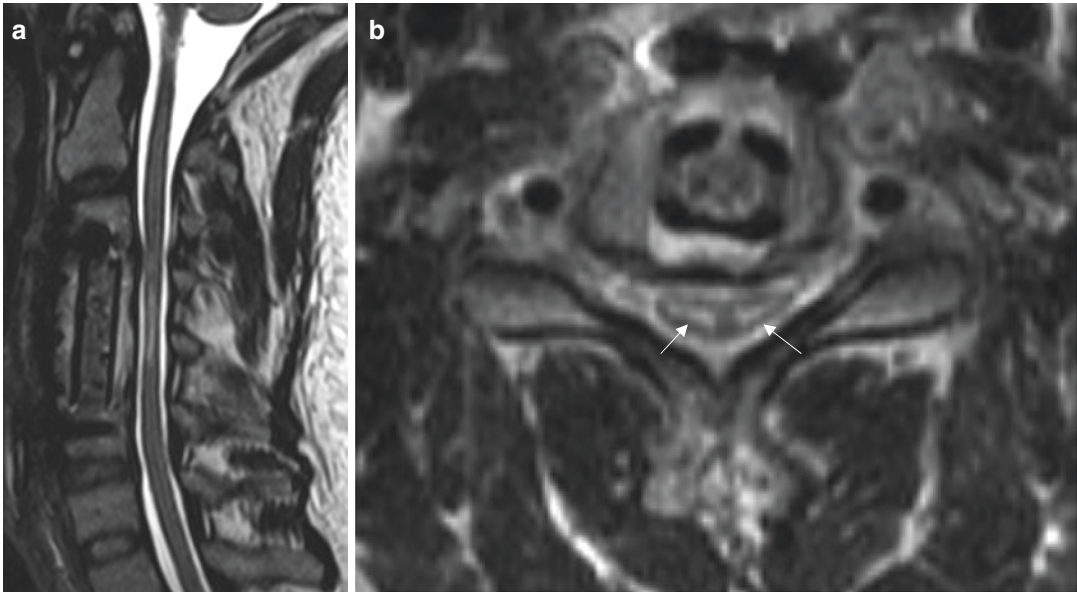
(a) Sagittal T2-weighted image in a postoperative patient demonstrates cord thinning and T2 hyperintensity from C3 to C5, compatible with myelomalacia. (b)
